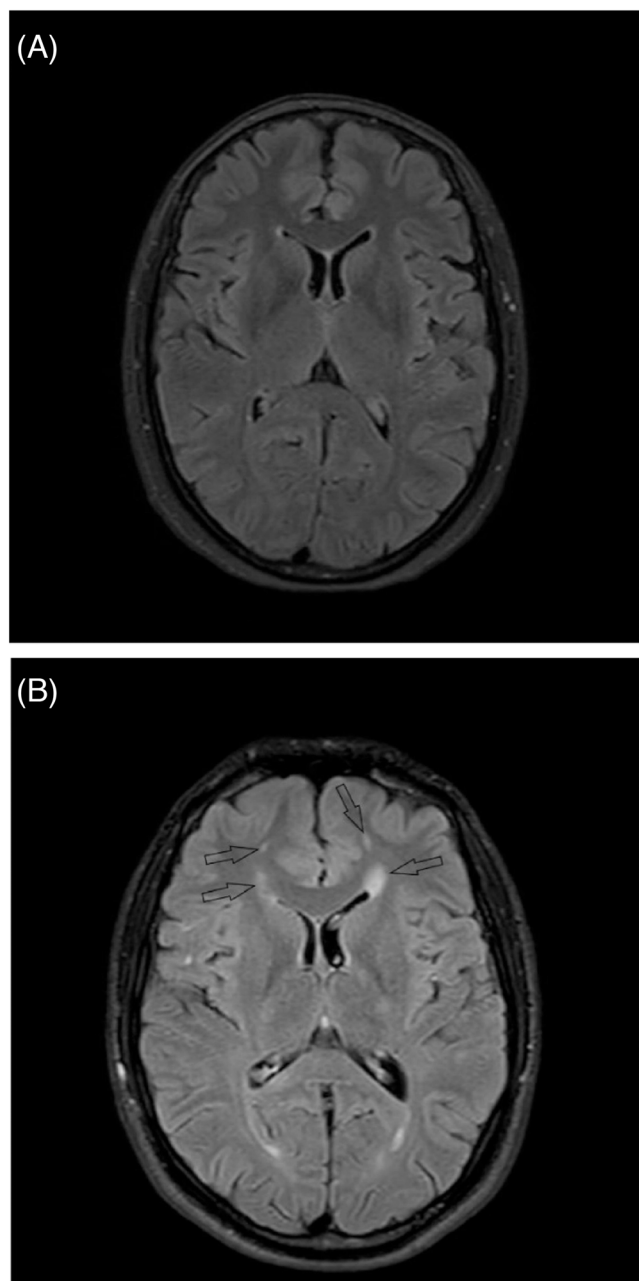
Examples of (A) normal and (B) abnormal brain magnetic resonance (MR) images in fluid-attenuated inversion recovery (FLAIR) sequence.
